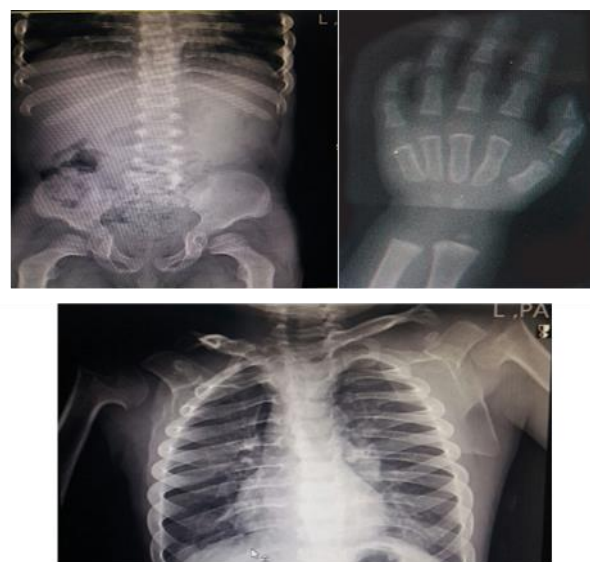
Hand, waist, pelvis and chest radiographs
